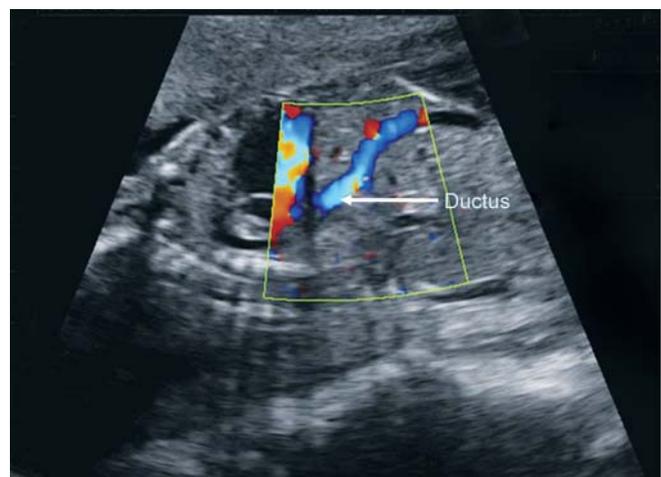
Ductus venosus color Doppler identification by aliasing phenomenon, caused by high velocity and turbulent flow in the ductus
